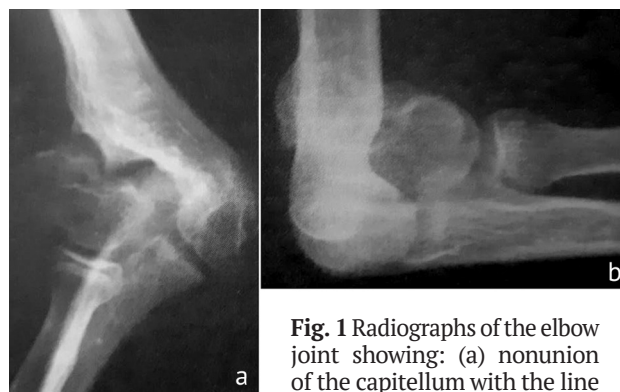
Radiographs of the elbow joint showing: (a) nonunion of the capitellum with the line passing through the olecranon fossa on the AP view, severe cubitus valgus, osteoporotic bone; (b) anterior displacement of the fragment can be seen on the lateral view with poor proximal alignment
